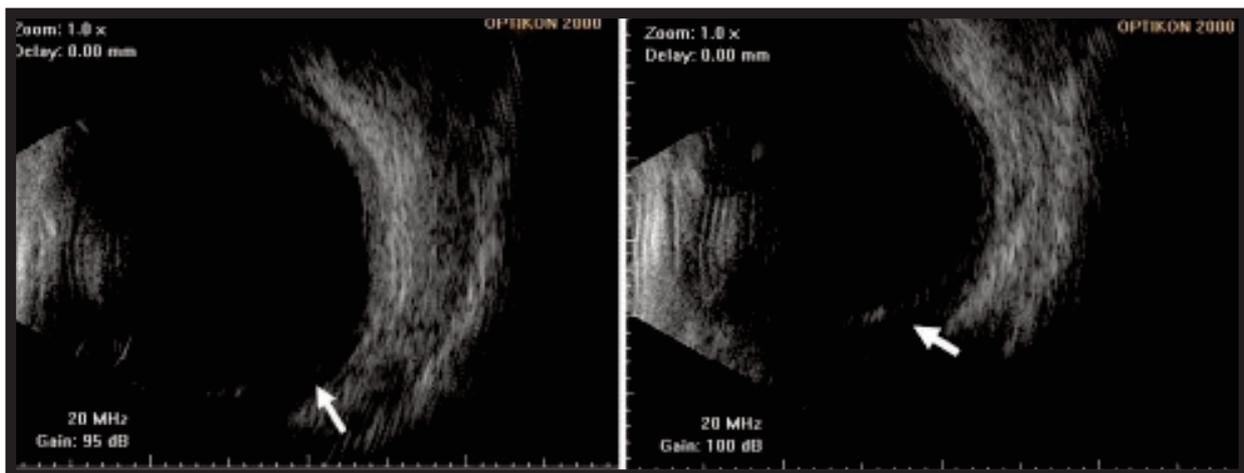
B-scan ultrasonography suggested bilateral mild peripheral choroidal effusions
